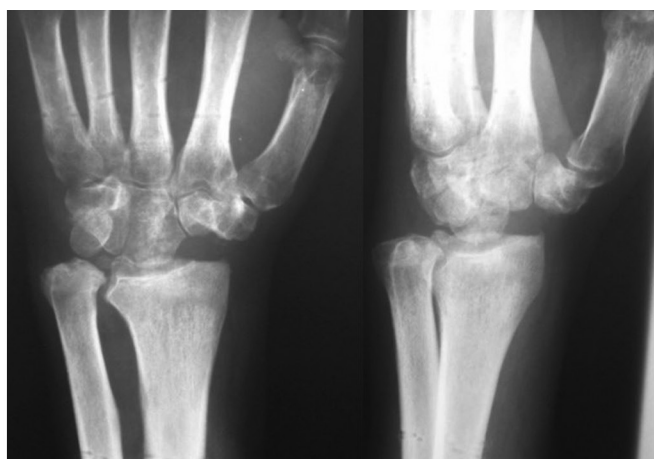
Treatment result. AP and lateral radiographs at 1-year follow-up
